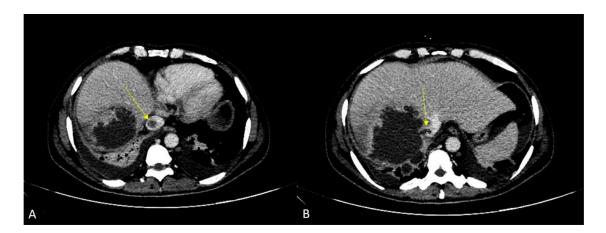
Case 2: Contrast-enhanced CT axial showing a hypodense filling defect in (A) suprahepatic (yellow arrow) and (B) intrahepatic IVC, seen communicating with the abscess (yellow arrow).
